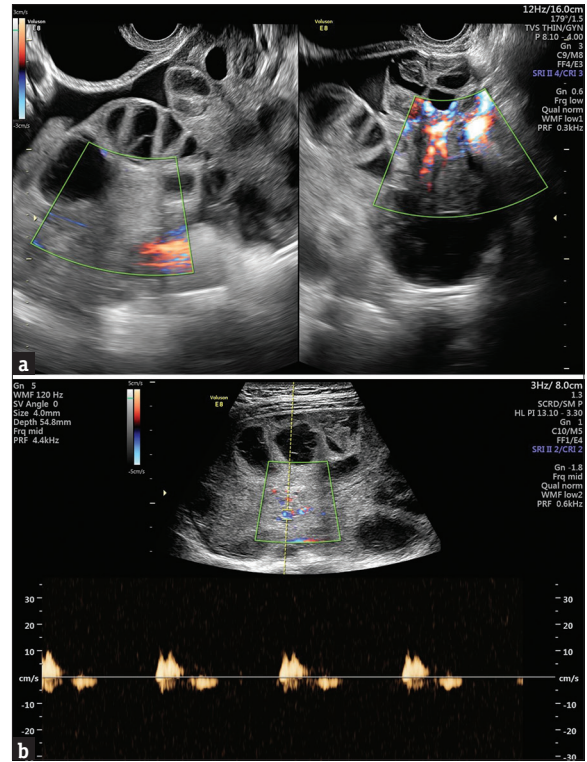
Postovocyte retrieval (day 4) ultrasonography showing significantly enlarged right ovary as compared to the left ovary
